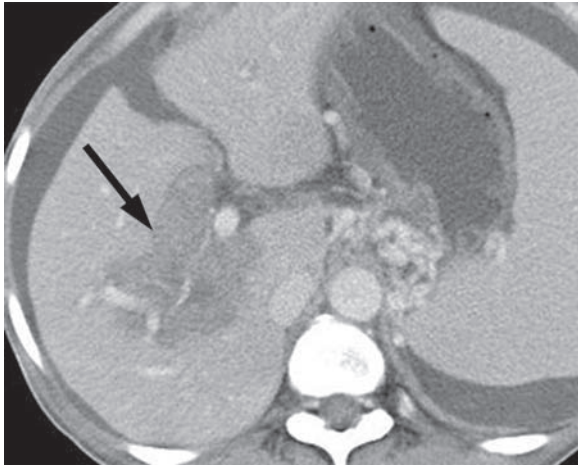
Periportal infiltration by extramedullary hematopoiesis in a 58-year-old woman with chronic myelogenous leukemia. Contrast-enhanced CT scan shows a well-defined soft-tissue mass encircling the right portal vein (arrow), along with ascites and splenomegaly.
